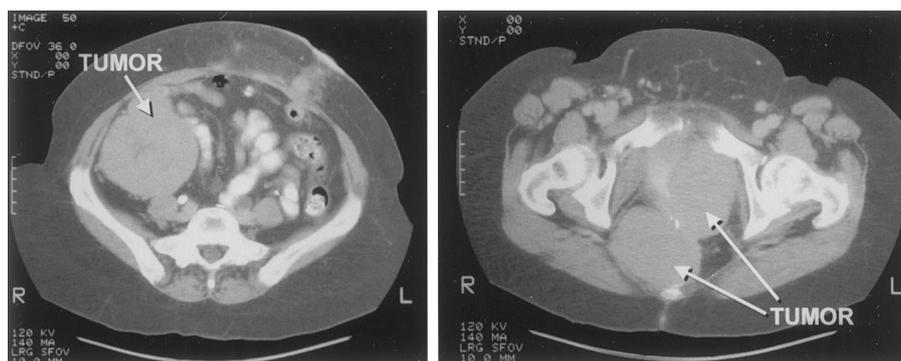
Preoperative abdominal and pelvic CT scan showing extensive intra-abdominal sarcoma.
